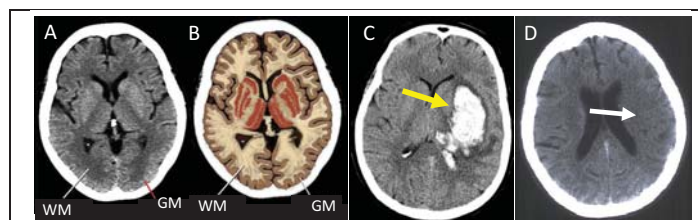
A NE-CT image (A) delineates the brain anatomy (B) accurately, including gray matter (GM)–white matter (WM) differentiation with 5–10 HU. WM has a greater fat content than GM, which makes it appear darker than GM on NE-CT. NE-CT clearly indicates a hyper-dense intracranial hemorrhage lesion (C, arrow), while NE-CT shows only a subtle hypo-dense signal at an acute ischemic lesion within a few hours of onset (D, arrow). Images are obtained from (A–B) <http://www.strokecenter.org/professionals/brain-anatomy/cellular-injury-during-ischemia/edema-formation/>, (C) [https://www.researchgate.net/figure/a-Ischemic-strokeshown-as-dark-black-area-b-Hemorrhagic-strokeshown-as-bright\\_fig1\\_40452206](https://www.researchgate.net/figure/a-Ischemic-strokeshown-as-dark-black-area-b-Hemorrhagic-strokeshown-as-bright_fig1_40452206), and (D) <http://slideplayer.com/slide/3883198/>.
